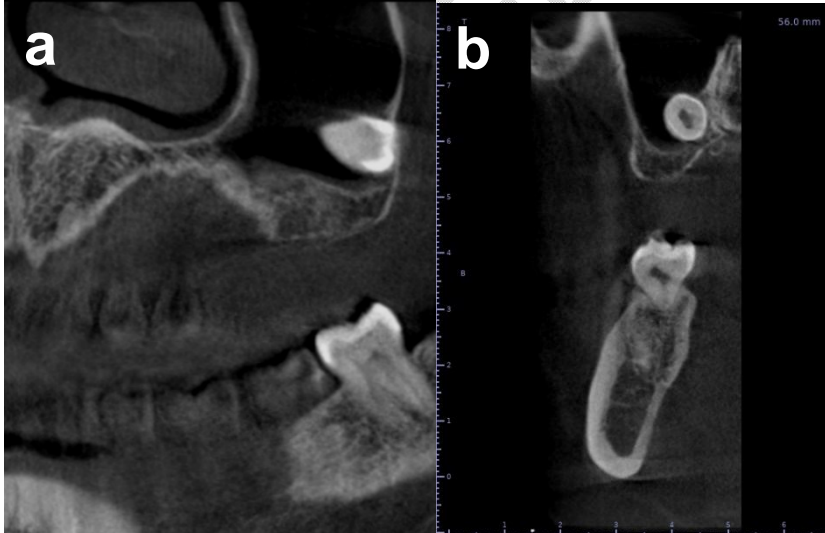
Multiplanar cone beam computed tomography (CBCT) sections: (a) coronal slices; (b) sagittal : showing the posteroinferior position of the ectopic left third maxillary molar inside the maxillary sinus.
